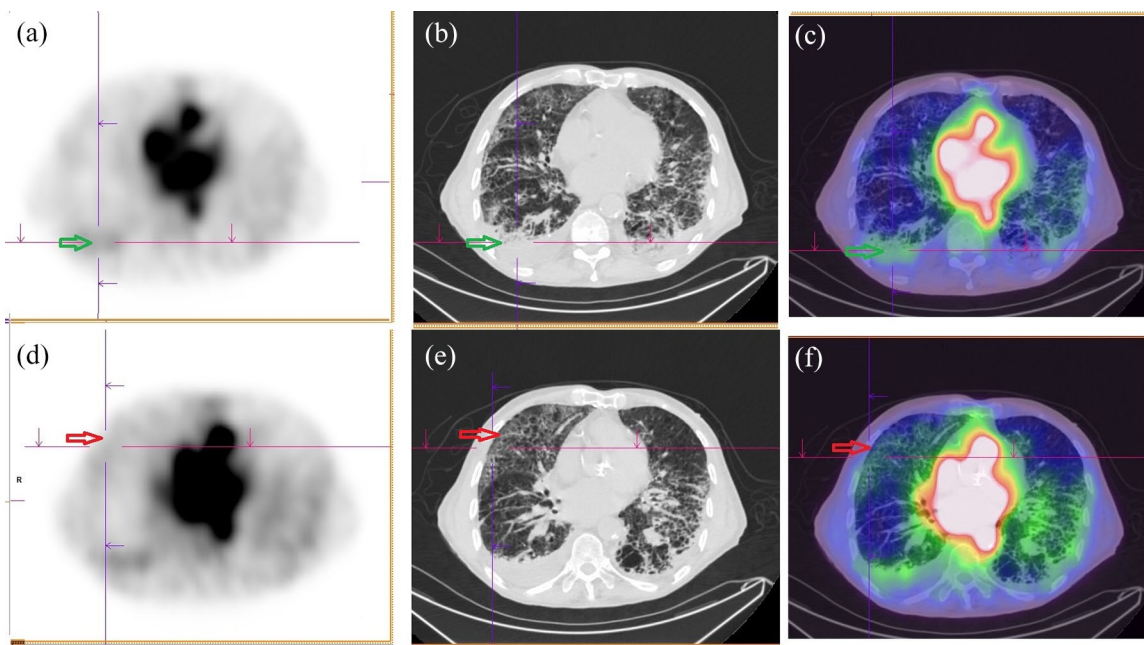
Patient no. 2. Albumin (a), CT (b), and fused CT + albumin scan (c). Green arrow: COVID-19 condensation of the right base with significant albumin uptake and moderate pleural effusion behind. There is also a moderate albumin uptake of the left inferior lobe. Albumin (d), CT (e), and fused CT + albumin scan (f). The moderate albumin uptake in the area of the peripheral halo of the COVID-19-involved area in the right superior lobe (red arrow) is related to the corresponding hyperperfusion displayed in Figure 2 (red arrow).
